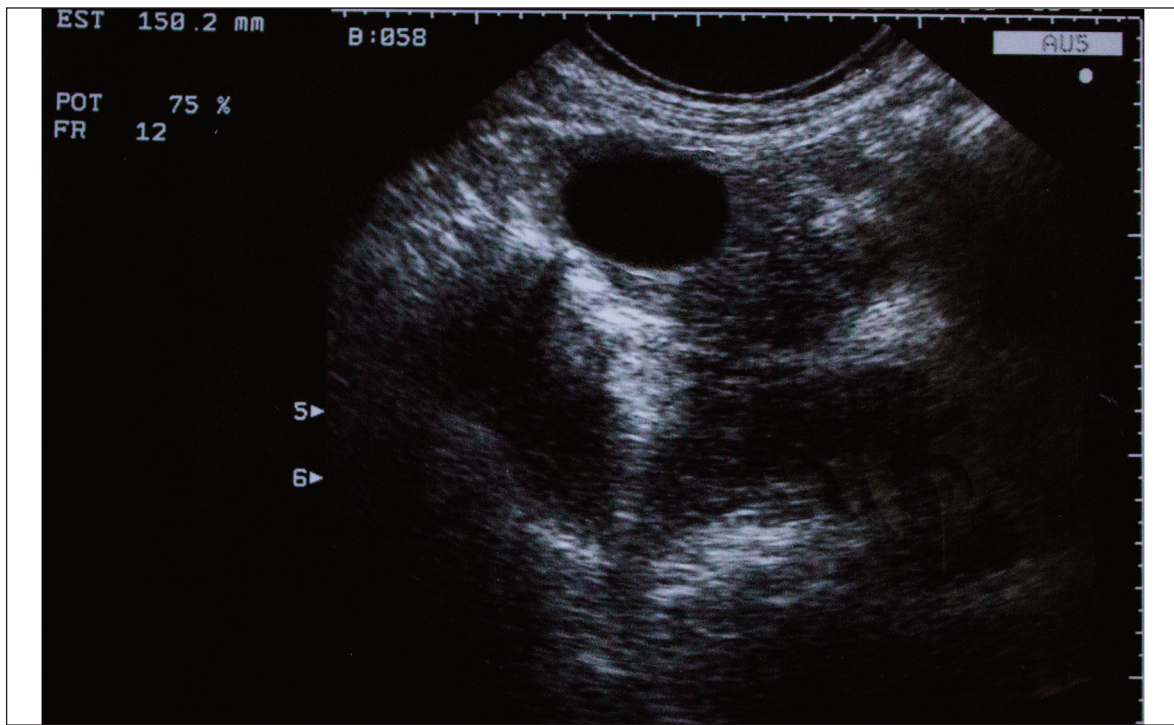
Ultrasonography image: simple liver cysts.
